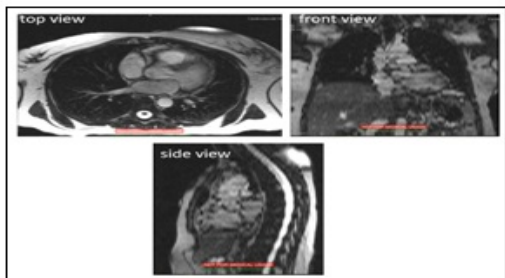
MRI slices from OsiriX.
